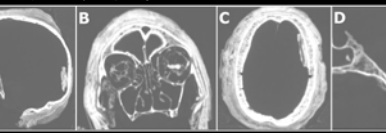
CT scan of Heteep-Bastet, showing (A) brain absence with a possible remaining fragment, (B) intact turbinates, nasal septum, and ethmoid air cells, (C) resin-impregnated linen adherent to the cranium internally, and (D) the margin of the wrappings in relation to the foramen magnum.
